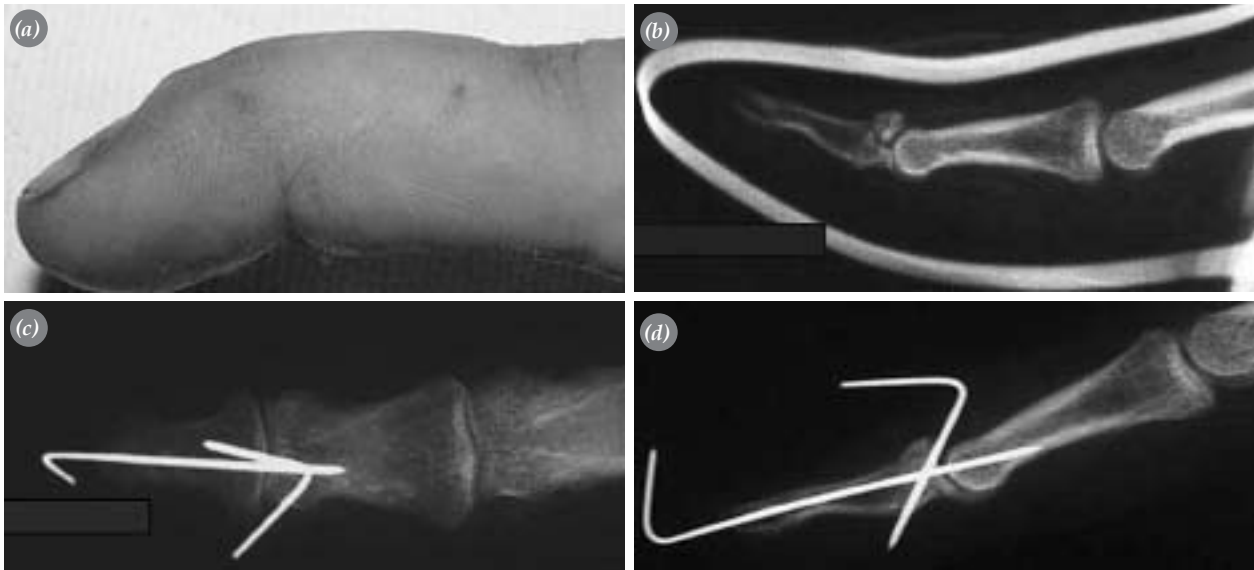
(a) The clinical figure of the patient. Mallet finger of the distal phalanx and extension insufficiency. (b) Insufficient reduction after closed reduction in the splint radiographically. After surgery, (c) anterior and (d) lateral radiographs. Reducing the fracture, the fragment was fixed with a K-wire and another K wire was used for stabilization intraarticularly.
